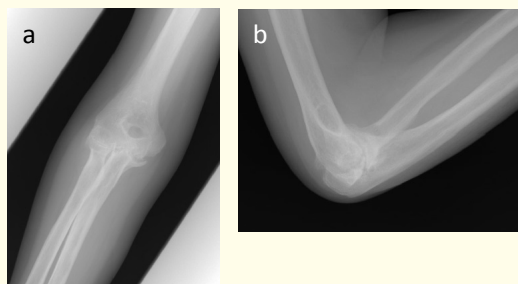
Preoperative plain radiographs.
